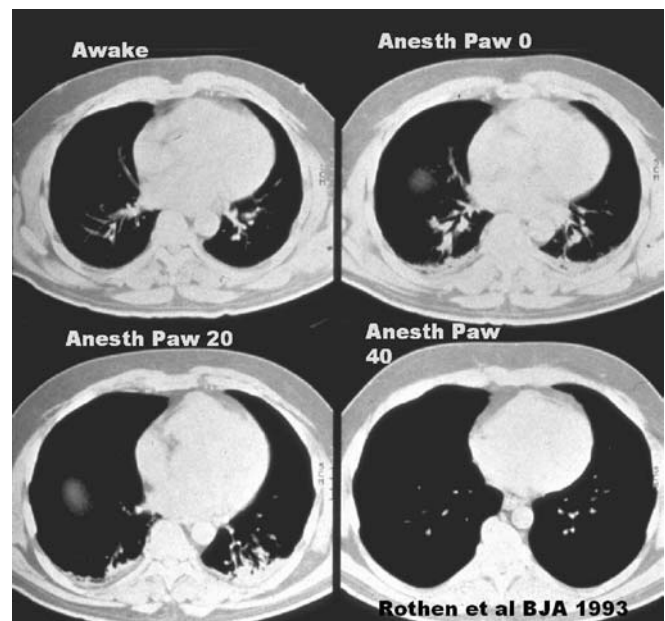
Computed tomography in a patient awake (*left upper*) during anesthesia at zero airway pressure (*Paw*), i.e., after a normal expiration (*right upper*), after an inflation to *Paw* 20 (*left lower*) and 40 cmH₂O (*right lower*) and a breath hold of 15 s. Note the appearance of atelectasis in the dorsal part of the lungs during anesthesia and the persistence of the atelectasis even with inflation to 20 cmH₂O. Not until *Paw* was increased to 30 cmH₂O did some of the atelectasis reopen. A *Paw* of 40 cmH₂O was required to open up all atelectasis (From [48] with permission from the publisher)
